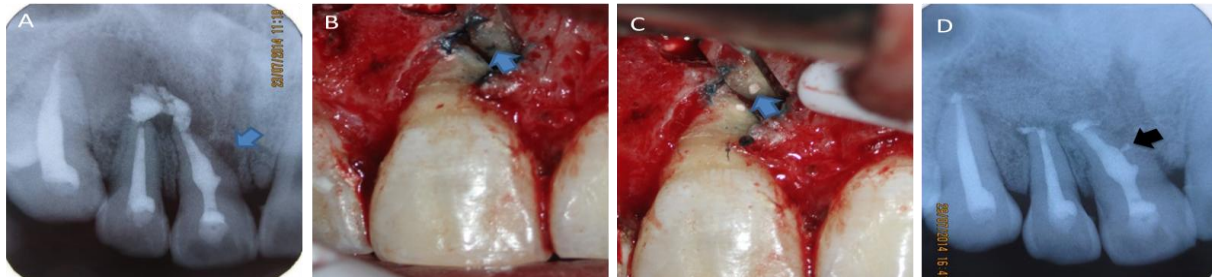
(A) The IOPA shows the presence of dumb-bell shaped periapical lesion involving periapical and mesial surface of maxillary central incisor. (B) Image shows the presence of lateral canal on mesiobuccal aspect of root surface (blue arrow). (C) The lateral canal sealed with MTA (blue arrow). (D) The IOPA confirms the seal of lateral canal.
